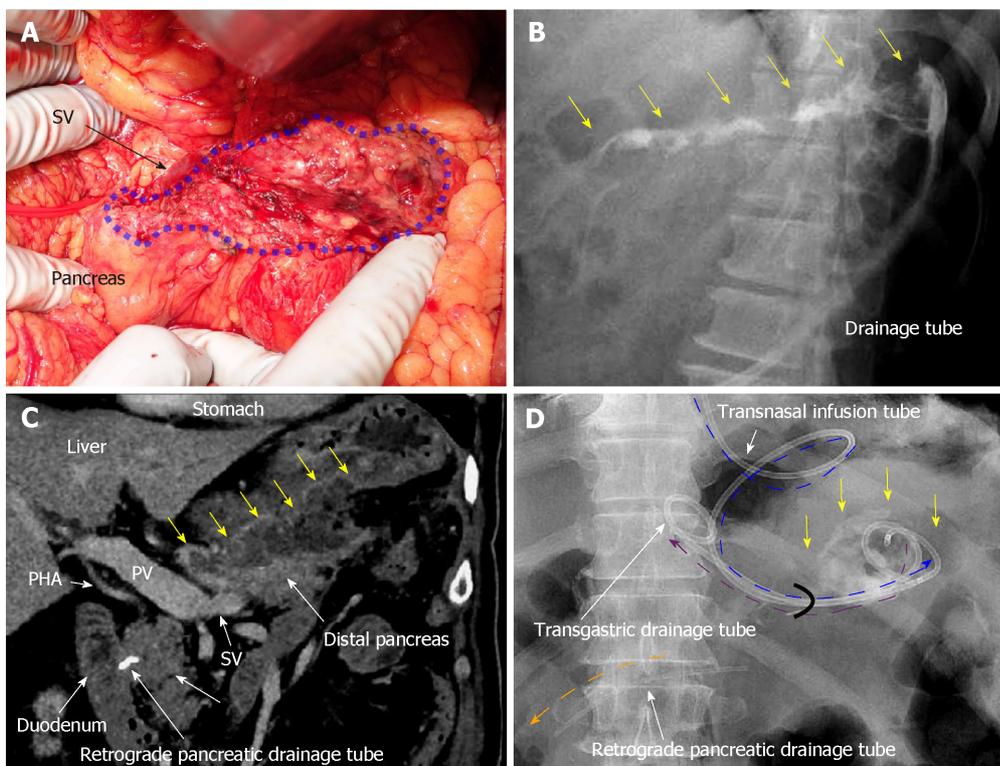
Case 3. A: Pancreatic parenchyma was preserved with the splenic vein, although the pancreatic parenchyma was widely exposed secondary to the aneurysmectomy (blue area); B: Optimal tube drainage (*i.e.*, intentional placement along the distal pancreas) could not be established because of difficulty using a percutaneous approach, and intractable pancreatic fistula along the distal pancreas (yellow arrows) was seen during fistulography on postoperative day (POD) 13; C: Intractable pancreatic fistula resulted in an abscess and localized peritonitis secondary to bacterial infection, and contrast computed tomography on POD 59 revealed an intraperitoneal abscess along the distal pancreas (yellow arrows); D: A retrograde pancreatic drainage tube (orange arrow) was placed endoscopically on POD 15. On POD 63, continuous local lavage (CLL) of the abscess cavity (yellow arrow) was initiated endoscopically *via* the transgastric route. Transnasal infusion was initiated and transgastric drainage tubes (purple and blue arrows) were placed endoscopically. From POD 63, saline irrigation was continuously injected *via* the transnasal infusion tube, and amylase levels in the lavaged fluid began to decrease immediately. Fistulography on POD 70 revealed resolution of the abscess after 1 wk of CLL. CLL: Continuous local lavage; PHA: Proper hepatic artery; POD: Postoperative day; PV: Portal vein; SV: Splenic vein.
